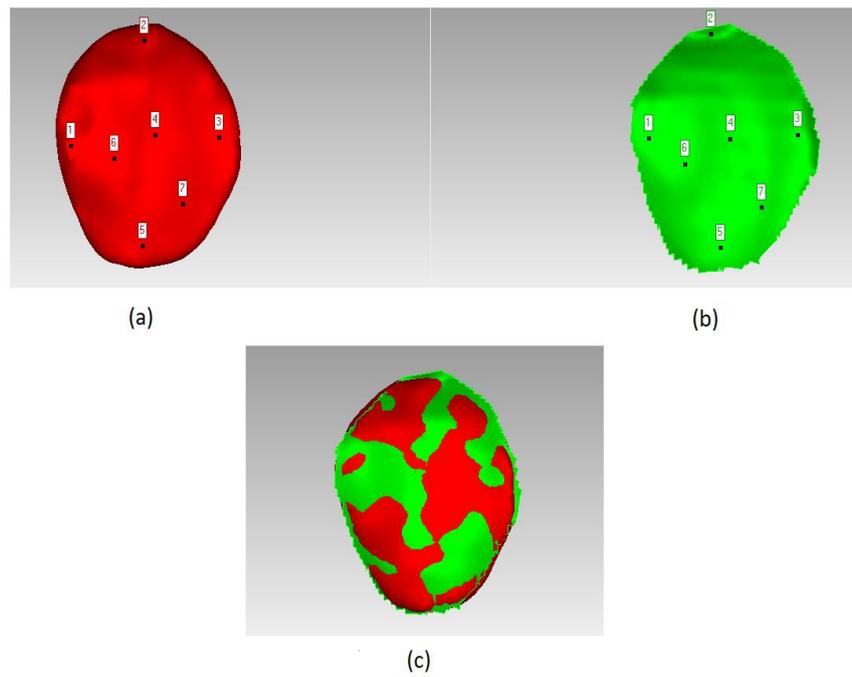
Manual registration by selecting random points over the lateral tibial surface (a): 3D model of the lateral tibial cartilage generated using pre-operative MRI scans. (b): Corresponding intra-operatively acquired 3D laser scan of the lateral tibial cartilage. (c): Registered models.
